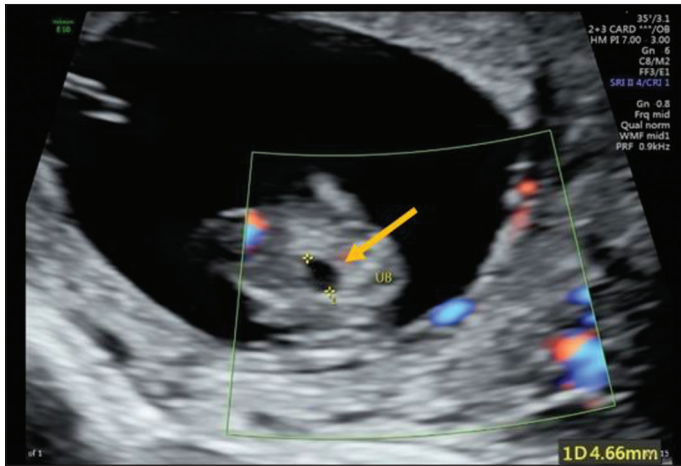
Images of first trimester anomaly Scan (13 weeks). Ultrasound with color Doppler in axial view at the level of the urinary bladder. Arrow showing non-visualization of the umbilical arteries on either side of the urinary bladder
